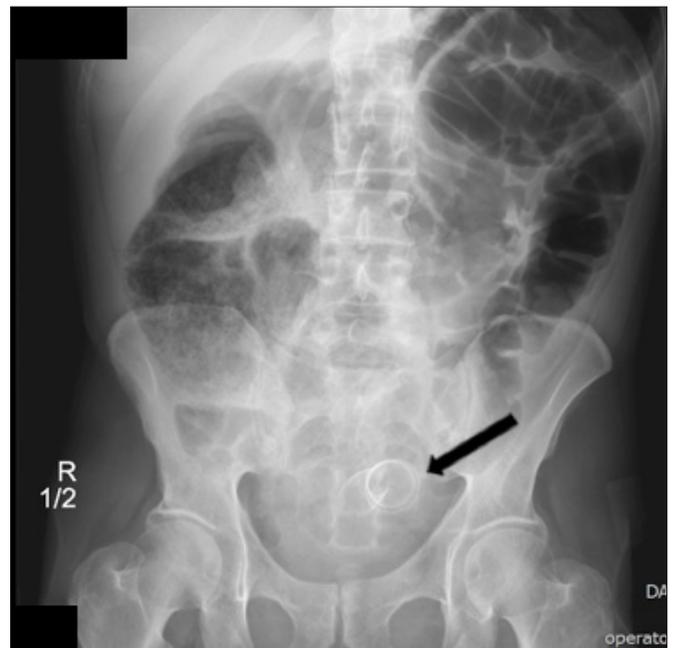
Abdominal X-ray: Dilated loops of bowel proximal to a colonic stent.
